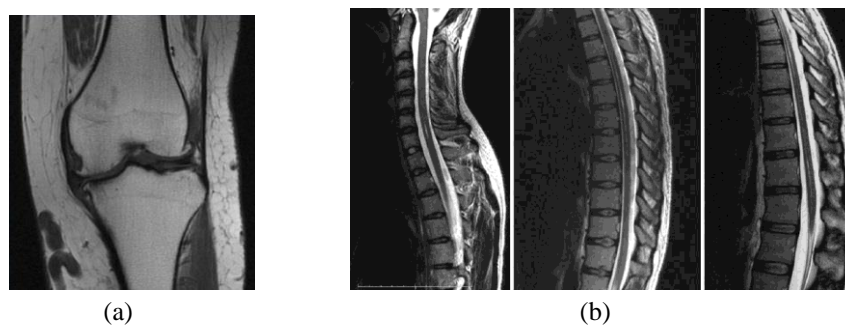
2: Examples MRI images (a) Knee (b) Right to Left: cervical, thoracic and lumbar spines
